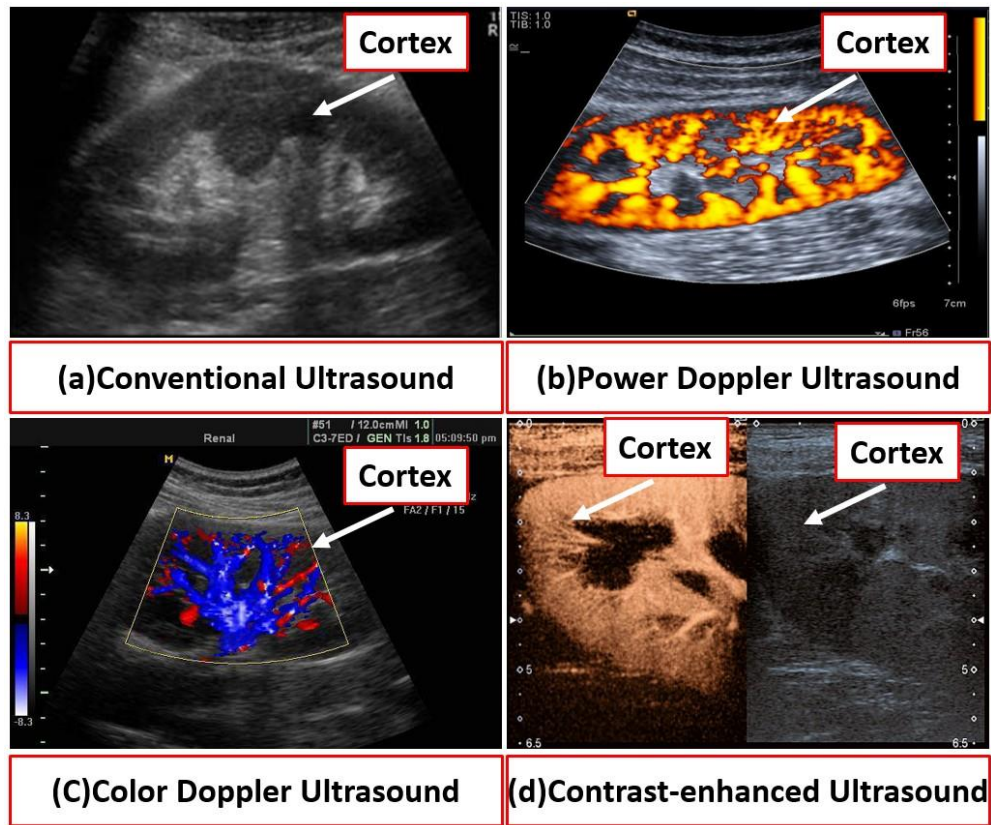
Example of different Ultrasounds.
